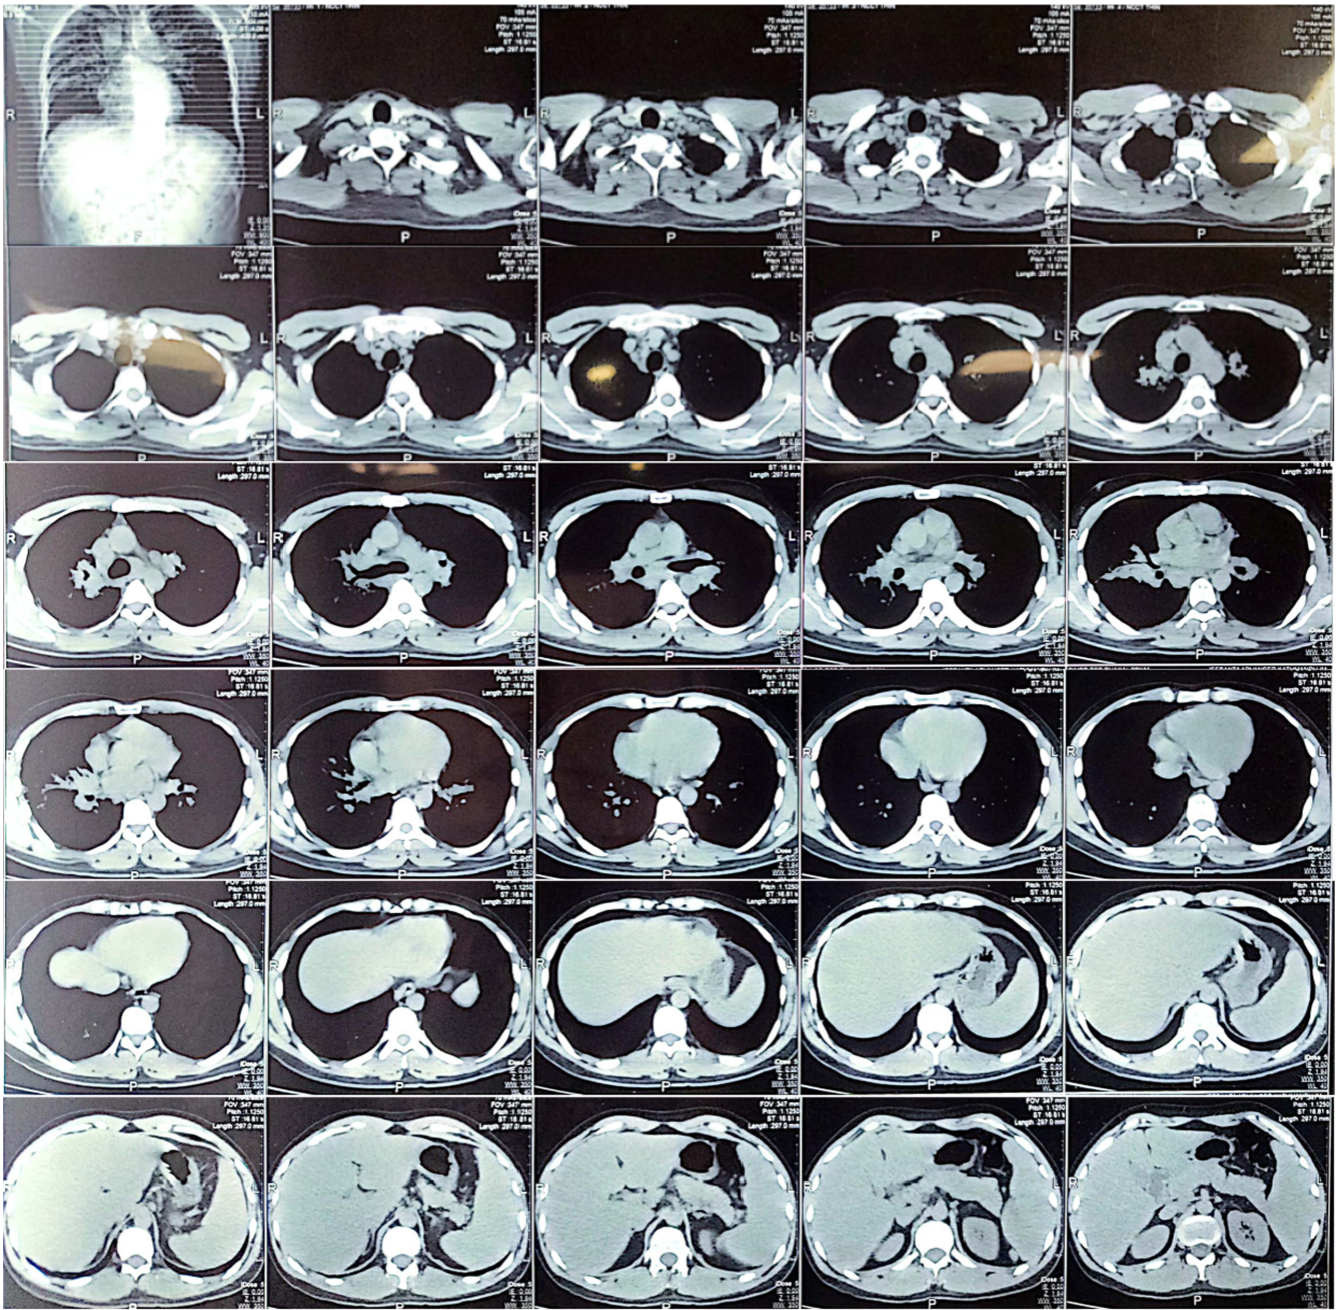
Transverse section of contrast-enhanced Computed Tomography (CT) of the chest revealing mild enhancement at the region of the nodule and consolidation.
